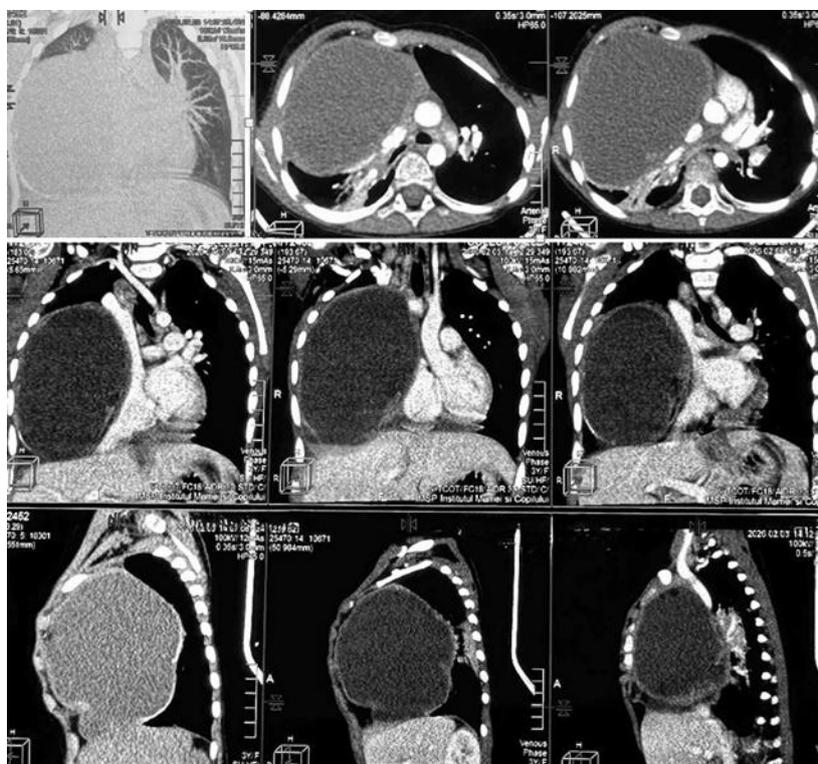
Patient E.C., 3 years old. CT imaging findings suggestive of a massive, multicomponent space-occupying lesion in the right hemithorax – possible teratoma? Incomplete vascular ring – aberrant right subclavian artery.
